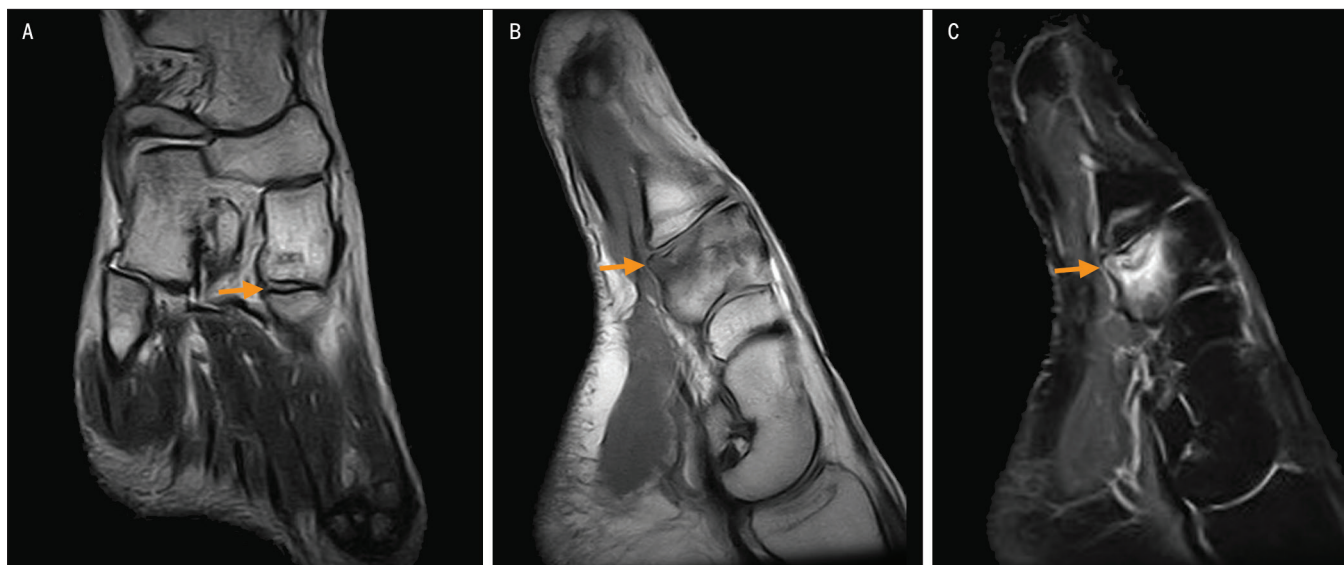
(A) Long-axis, axial, T2-weighted right-foot magnetic resonance image demonstrating cortical irregularity (arrow). (B) Sagittal, T1-weighted right-foot magnetic resonance image demonstrating signal hypointensity (arrow). (C) Sagittal, short-tau inversion recovery, weighted right-foot magnetic resonance image demonstrating signal hyperintensity (arrow) of the medial cuneiform without involvement of the plantar metatarsal ligaments, consistent with an isolated medial cuneiform impaction fracture.
